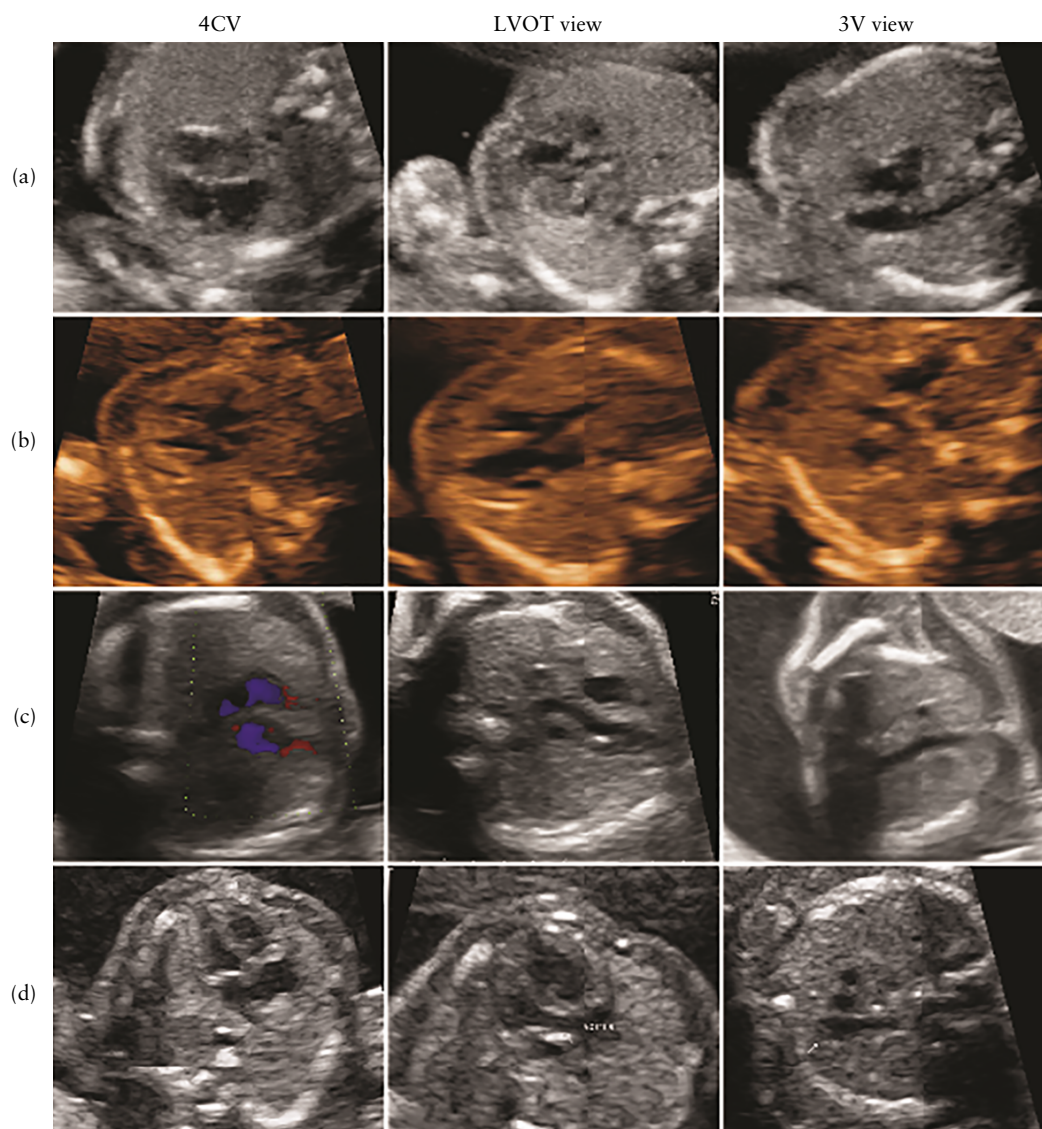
Ultrasound images of fetal heart in four-chamber (4CV), left ventricular outflow tract (LVOT) and three-vessel (3V) views in four cases with severe congenital heart disease at birth that was missed on prenatal ultrasound examination due to poor adaptational skills of sonographer (a), inability of sonographer to recognize defect (b,c) or defect not being visible despite adequate image quality (d). (a) Case of atrioventricular septal defect missed prenatally due to poor adaptational skills of sonographer. In 4CV, atria are blurred, plane is not taken at proper level (too far towards diaphragm, showing atrioventricular valve annuli instead of valves). Only ventricles and septum are visible. LVOT view quality was scored 1 as aorta is barely recognizable. (b) Case of tetralogy of Fallot that was not recognized by sonographer; although quality of planes is inadequate (total score of 6), ventricular septal defect can be identified with over-riding aorta. In 3V view, it is clearly visible that pulmonary artery is small and ascending aorta is relatively large. Right aortic arch is visible just anterior to spine. (c) Case of transposition of great arteries that was not recognized by sonographer despite planes having adequate quality score; as only two vessels (right superior caval vein and ascending aorta arising from right ventricle) are visible in 3V view, which is typical for this diagnosis. (d) Case of coarctation of aorta that was classified as inevitably missed, as quality of cardiac examination was adequate (total score of ≥ 12), and in particular, no discrepancies in size of ventricles or great arteries were evident on any cardiac images obtained.
